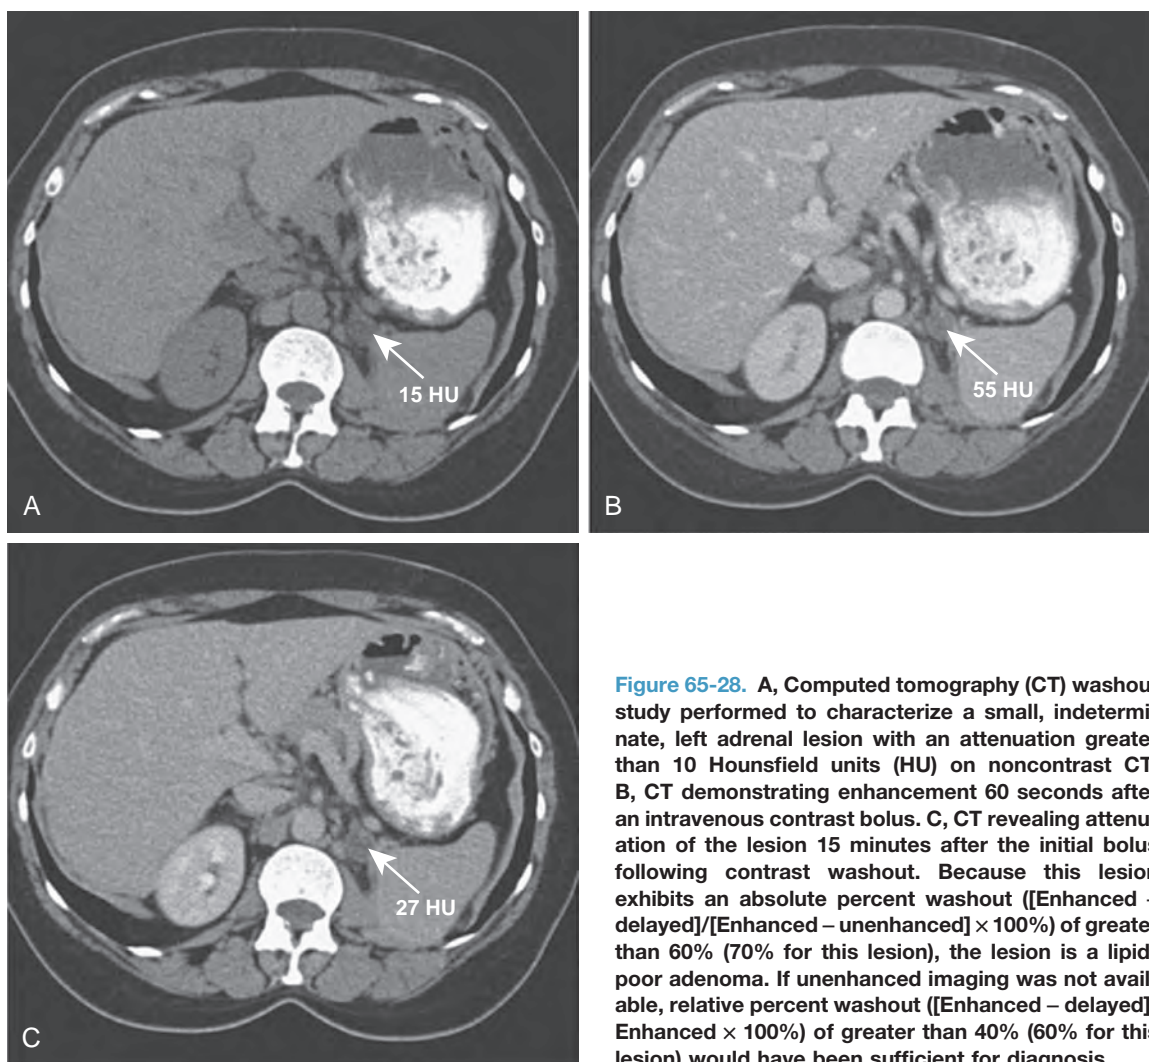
A, Computed tomography (CT) washout study performed to characterize a small, indeterminate, left adrenal lesion with an attenuation greater than 10 Hounsfield units (HU) on noncontrast CT. B, CT demonstrating enhancement 60 seconds after an intravenous contrast bolus. C, CT revealing attenuation of the lesion 15 minutes after the initial bolus following contrast washout. Because this lesion exhibits an absolute percent washout $\left(\frac{[\text{Enhanced} - \text{delayed}]}{[\text{Enhanced} - \text{unenhanced}]} \times 100\%\right)$ of greater than 60% (70% for this lesion), the lesion is a lipid-poor adenoma. If unenhanced imaging was not available, relative percent washout $\left(\frac{[\text{Enhanced} - \text{delayed}]}{\text{Enhanced}} \times 100\%\right)$ of greater than 40% (60% for this lesion) would have been sufficient for diagnosis.
